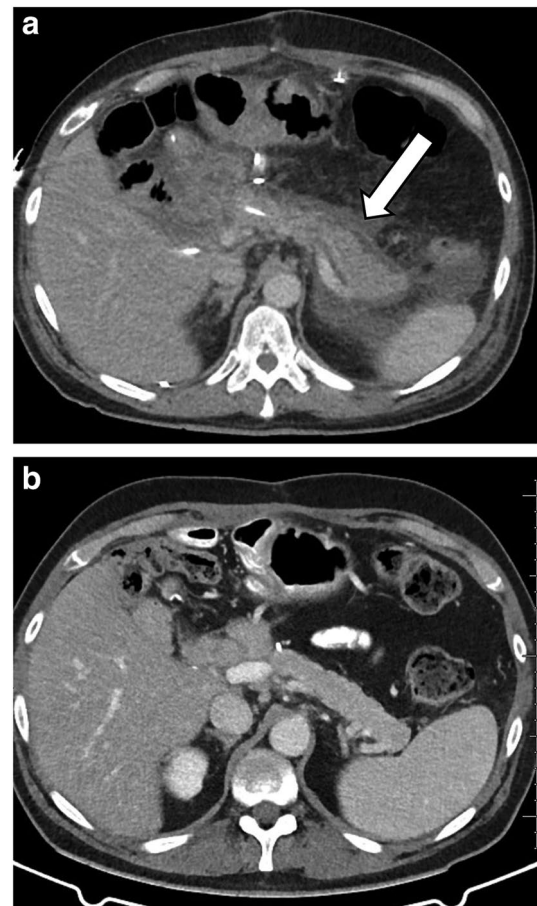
Normal post-surgical findings after resection procedures for chronic pancreatitis. Axial contrast-enhanced CT images immediately (a) and 3 months post-Whipple resection shows moderate peripancreatic fluid (arrow in a), which resolved on follow-up (b)
